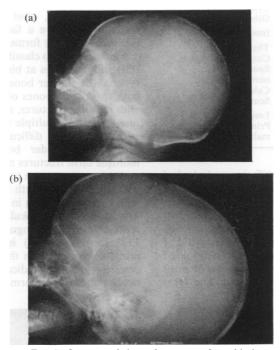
Osteogenesis imperfect a congenita—thin bone type. Skull X-rays at (a) 1 week and (b) 7 months to show the very thin skull at birth which then rapidly ossifies.
